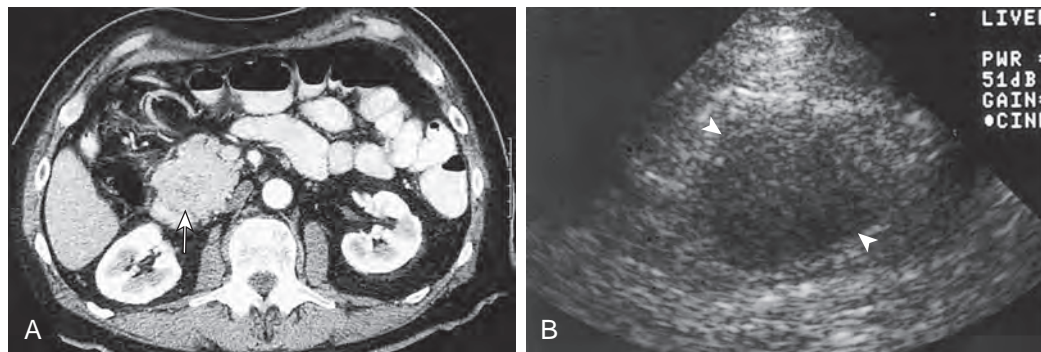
Images of a 57-year-old man with abdominal pain and weight loss. A. Axial CT of the upper abdomen with contrast material reveals a rounded fullness in the pancreatic head with subtle hypoattenuation changes (arrow). Note numerous blood vessels anterolateral to the pancreatic head as well as colon and jejunum anteromedially. B. Gray-scale ultrasound in the transverse plane reveals a hypoechoic, rounded mass in the region of the pancreatic head (arrowheads). Note that with transducer compression, there has been considerable decrease in the distance from the skin to the mass as well as displacement of intervening bowel. Fine-needle aspiration revealed adenocarcinoma.
